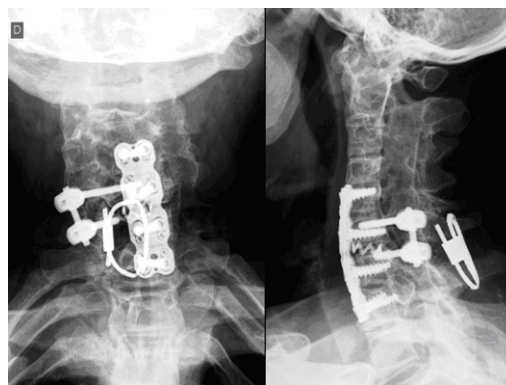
Post-operative plain X-rays.
